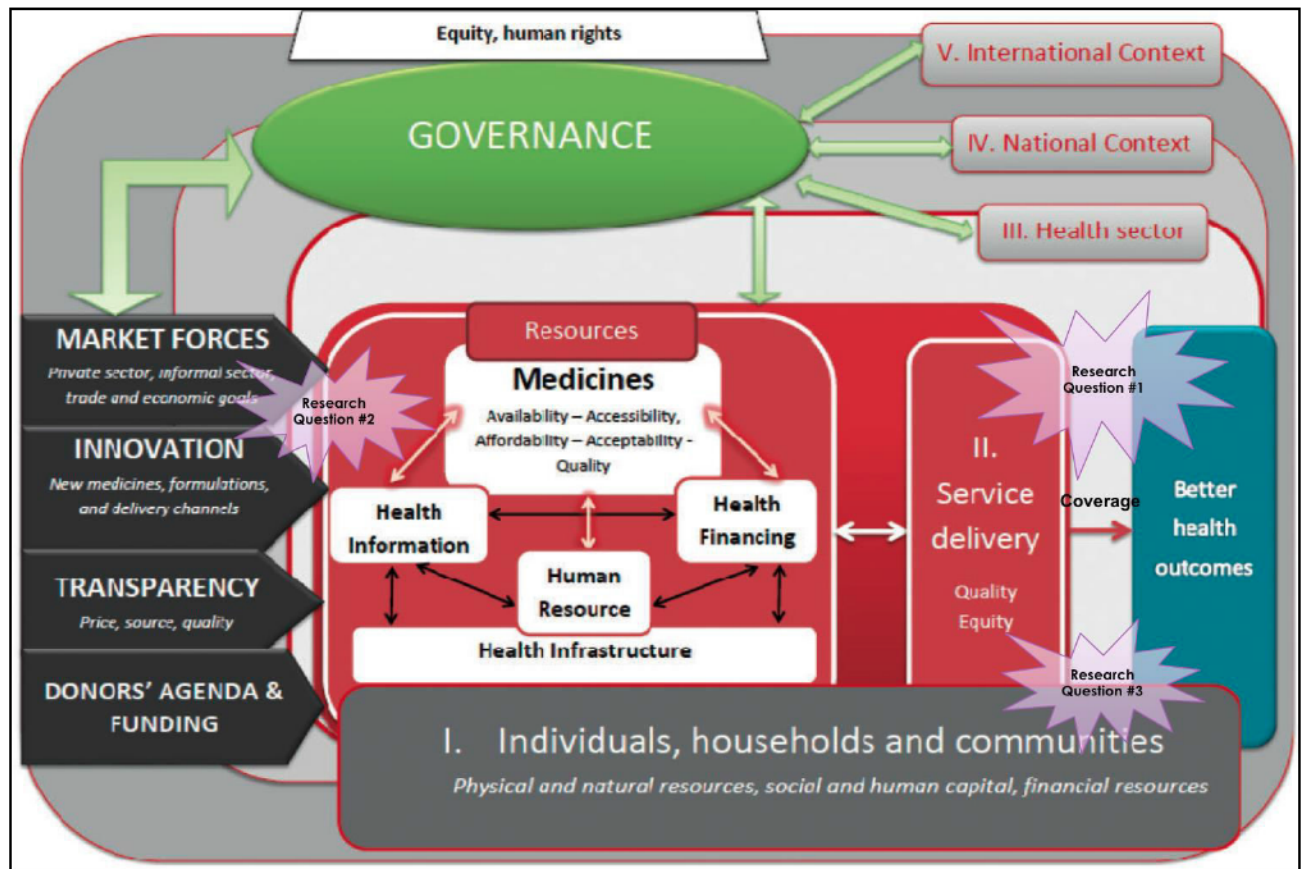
5: ACCESS TO MEDICINES FROM A HEALTH SYSTEMS PERSPECTIVE
